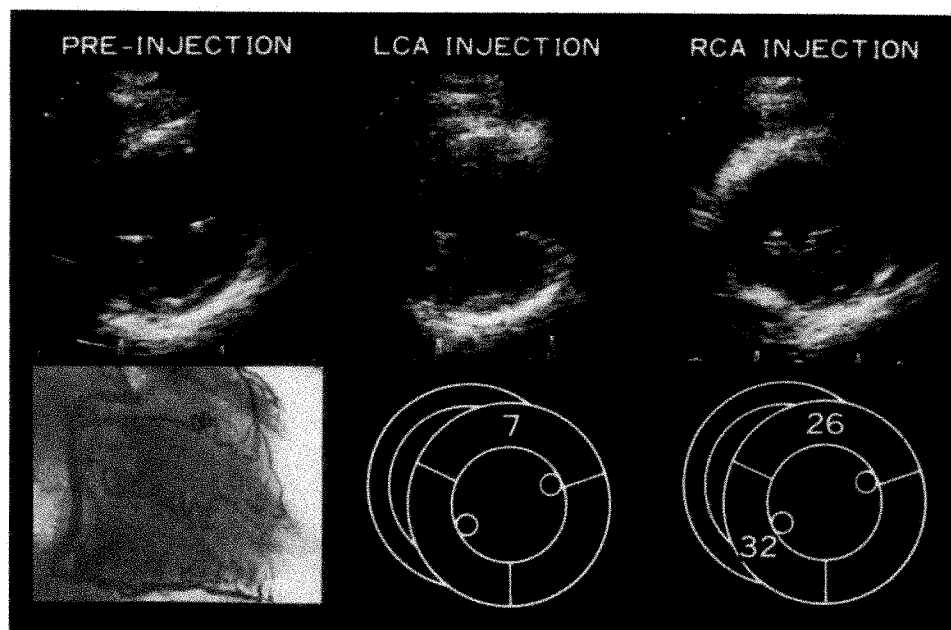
Myocardial contrast echocardiograms in a patient with anteroseptal infarction with good collateral vessels from the right coronary artery (RCA) to the left anterior descending artery. End-diastolic images before coronary artery injection (upper left panel) and after left coronary artery (LCA) injection (upper middle panel) and RCA injection (upper right panel). Lower left panel shows right coronary angiogram of this patient. Lower middle and right panels show the values of peak background-subtracted gray level in the corresponding region during LCA and RCA injections, respectively. Anteroseptal region shows good contrast enhancement during the RCA injection.
